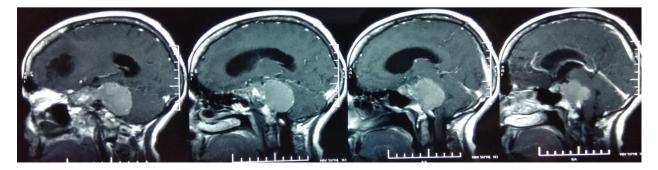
MRI Brain contrast images showing brilliantly homogenous contrast enhancing lesion in cavernous sinus with extension to the right cerebellopontine angle.
